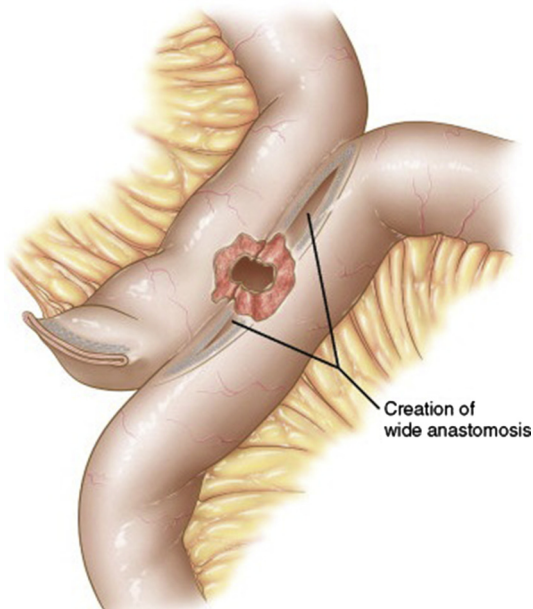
A curved dissector is used to position the open enterotomy for the third and final firing of the linear stapler. (From Zografakis JG, Frantzides CT. Laparoscopic Gastric Bypass with Roux-en-Y Gastrojejunostomy. In: Frantzides CT, Carlson MA, editors. Atlas of Minimally Invasive Surgery. Philadelphia: Elsevier Saunders; 2009. p. 53–66; with permission.)
